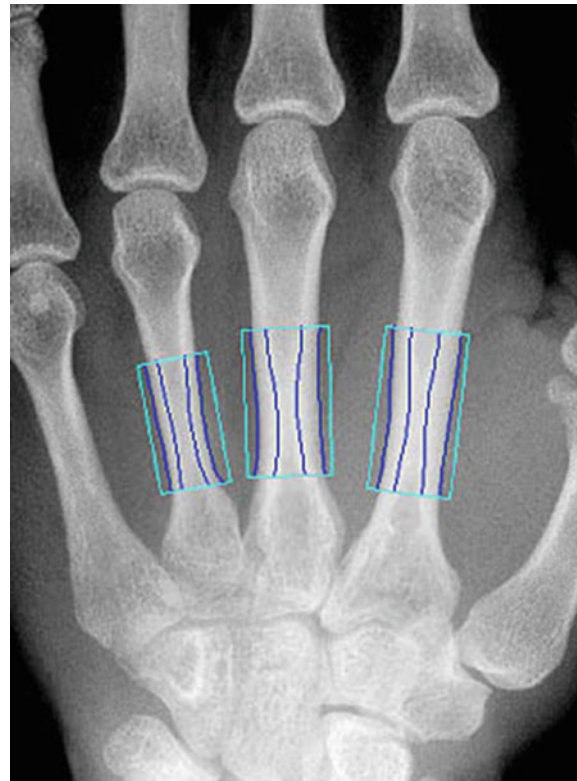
Radiographs of the hand showing a detailed evaluation of II, III, and IV metacarpal bones. Spongy and cortical compartments are separately evaluated
